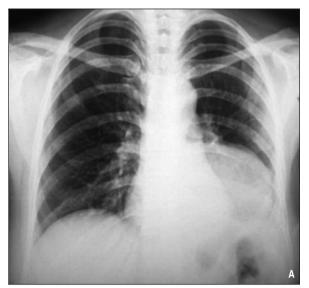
Chest X-ray before (A) and after treatment (B).
